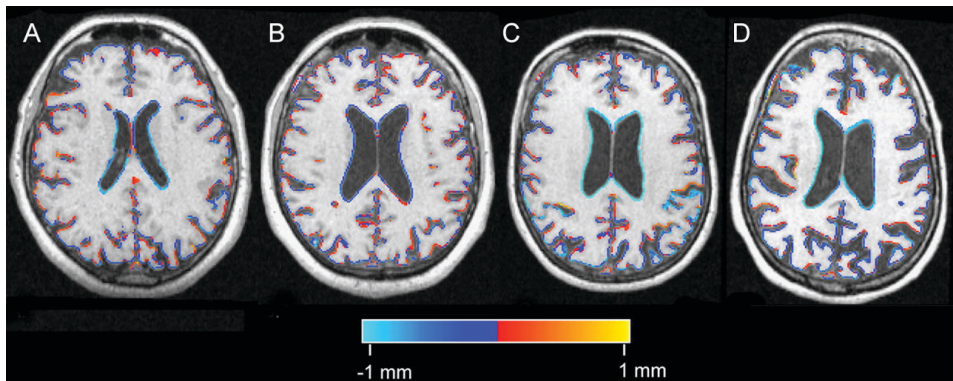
Four examples of individual edge-displacement maps, overlaid on baseline axial MR images. Dark-blue to light-blue represents mild to severe local contraction respectively, which implies atrophy. Red to yellow indicates mild to severe expansion of brain tissue. Note that for display purposes, edge motion was truncated at 1 mm in this figure. (A) patient with subjective complaints (age, normalised baseline brain volume, whole-brain atrophy rate: 74 y, 1471mL, -0.7%/y), (B) a patient with Mild Cognitive Impairment, who did not progress to AD (80y, 1607mL, -0.6%/y), (C) a patient with Mild Cognitive Impairment, who progressed to AD (67 y, 1548 mL, -1.9 %/y) and (D) a patient diagnosed with Alzheimer's disease at baseline (63 y, 1286mL, -4.2%/y).
